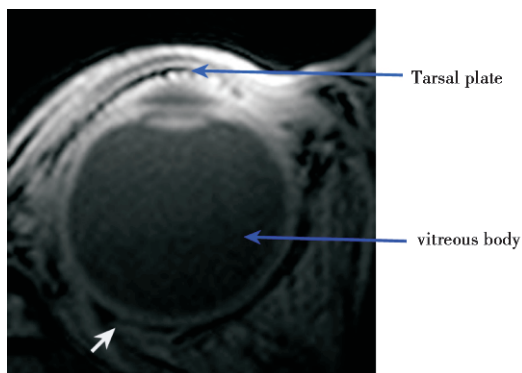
Axial FFE sequence T₁WI HR-MR image. The layers of the tarsal plate are depicted
